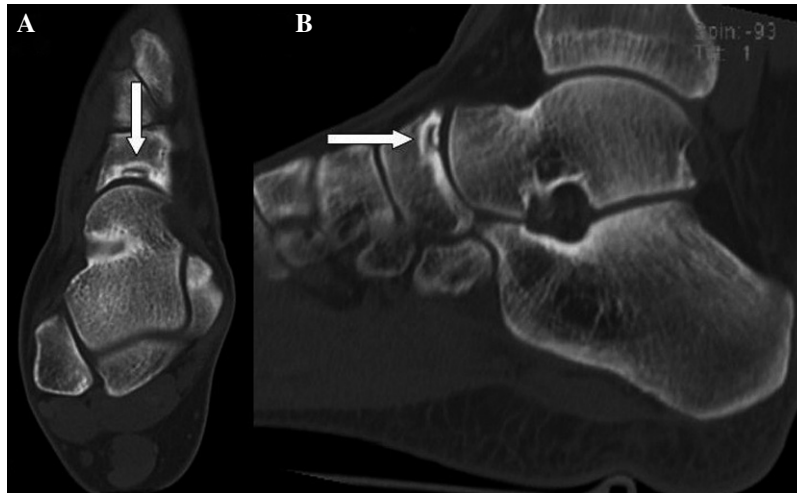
CT scans in the axial (A) and sagittal (B) planes show a nondisplaced osteochondral fragment within the cocavity of the tarsal navicular (arrows).
